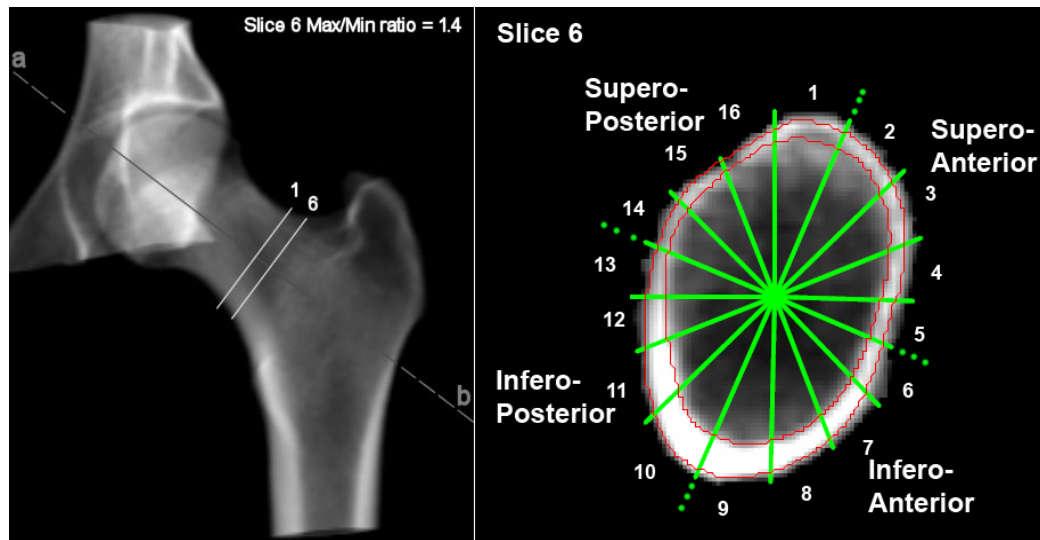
3D CT rendering (left) showing ROIs and Slice Position. Shape of FN at max/min ratio 1.4 (right) showing anatomical quadrants (note the clockwise shift of one sector due to sagittal positioning). The red contours show the cortex.
